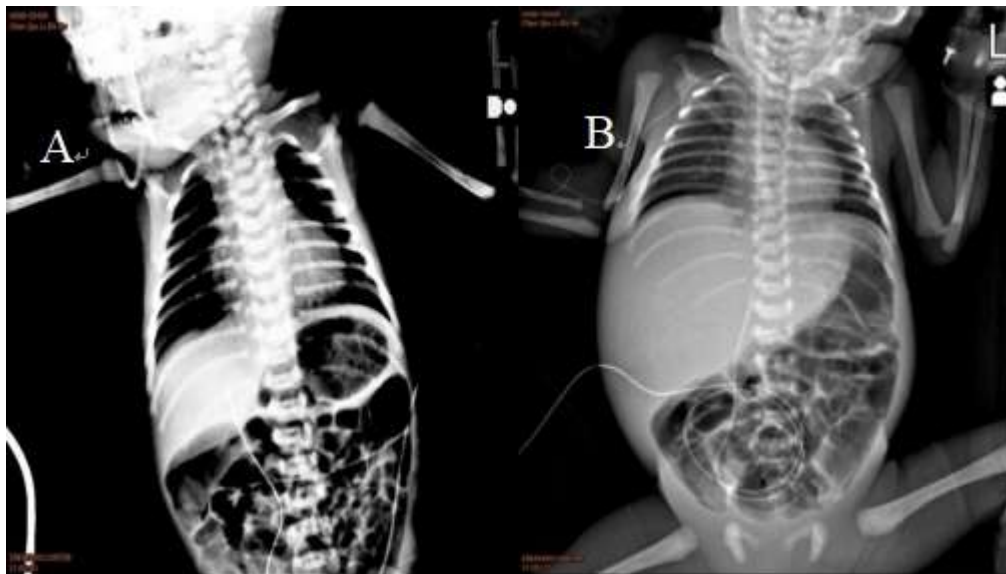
A) Abdominal X-ray showing the tip of the catheter to the right of the vertebral column at the level of the T₁₀ vertebra. B) Abdominal X-ray of the patient on the 6th day of umbilical venous catheter placement. The tip of the catheter is at the level of the T12 vertebra.
